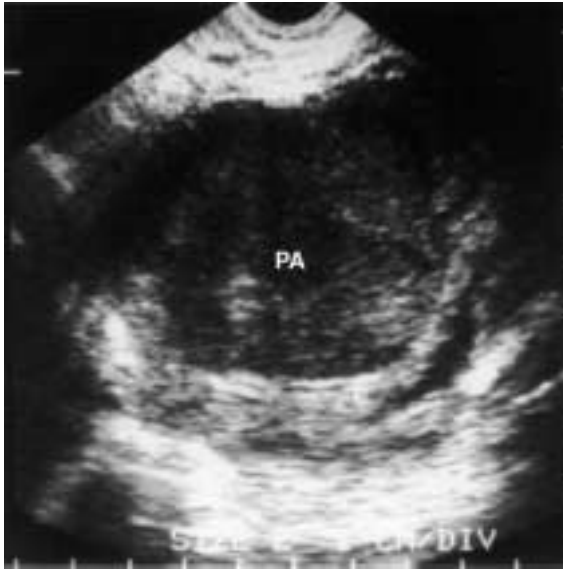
Transvaginal ultrasound image of a pelvic abscess (PA).
